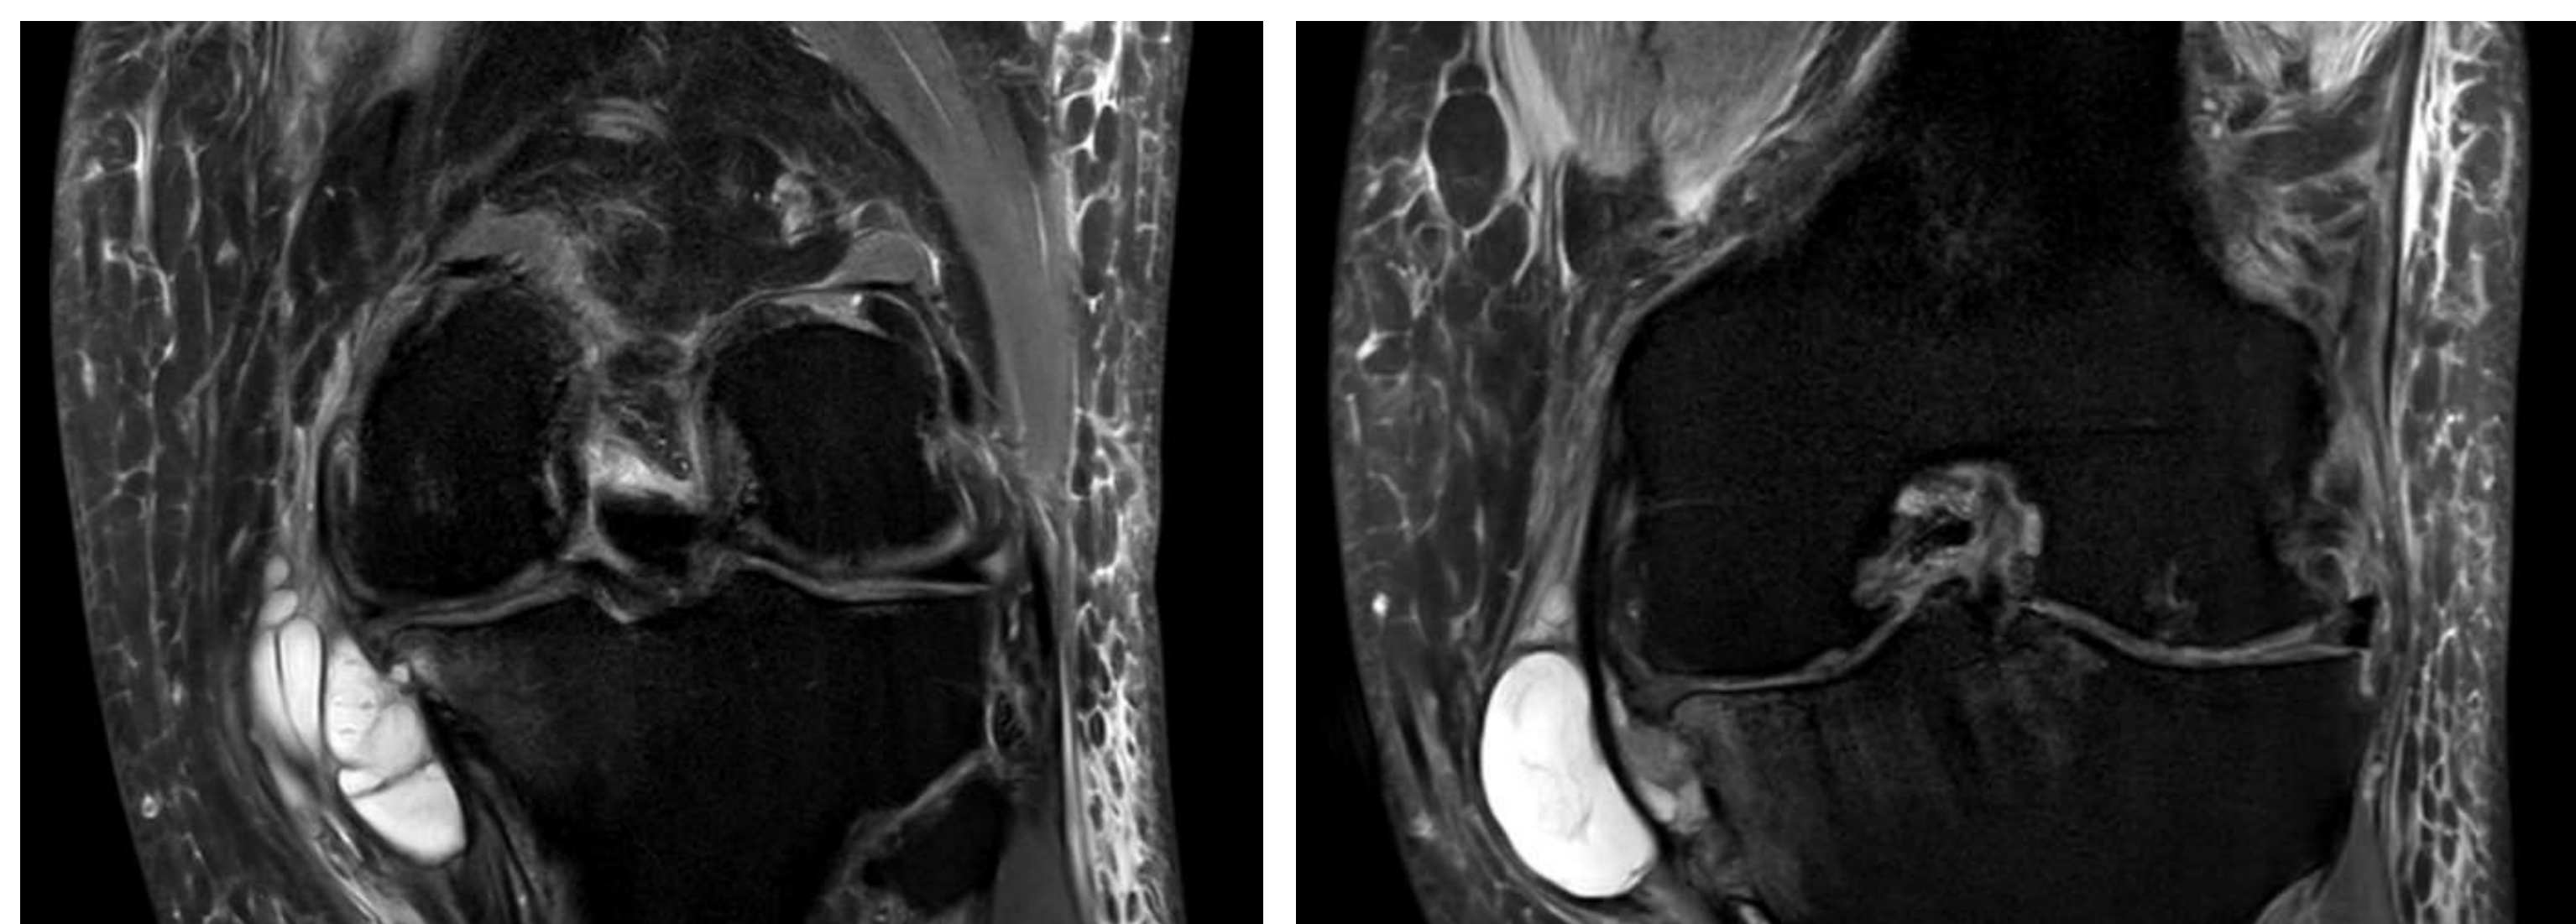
Two coronal MR images of left knee obtained a year before the patient's presentation. A medial multiseptated parameniscal cyst was seen in the same location as the cyst seen on the later CT, albeit smaller. No gas is seen within the cyst.
